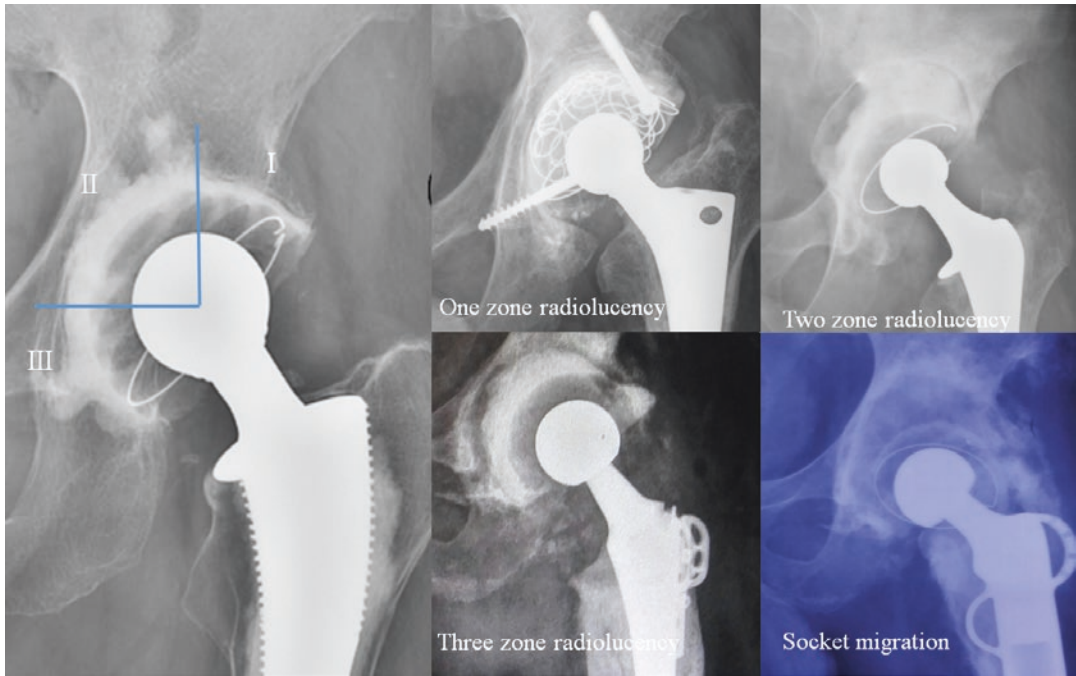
Radiographic assessment of a cemented cup
